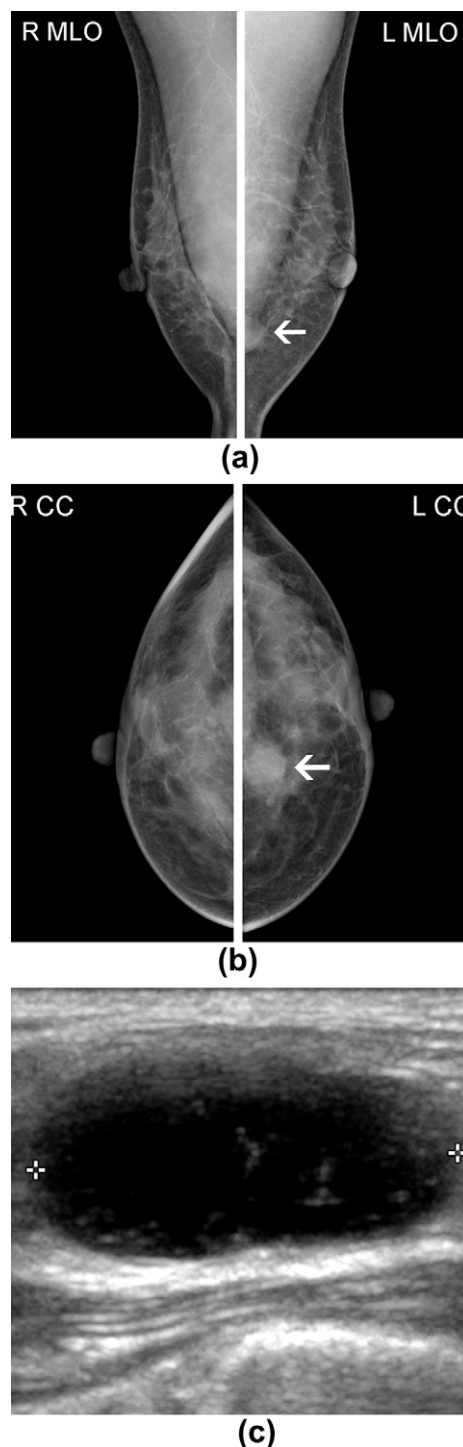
(a) MLO and (b) CC views of the same patient demonstrate increased density within the pectoralis muscles with slight bulging on the left and a more focal ill-defined lesion (arrow) within the left breast. (c) The corresponding ultrasound image of the focal lesion is largely anechoic with some internal echoes. Macrolane deposits were also seen within the pectoralis muscle on ultrasound (see Fig 6).
